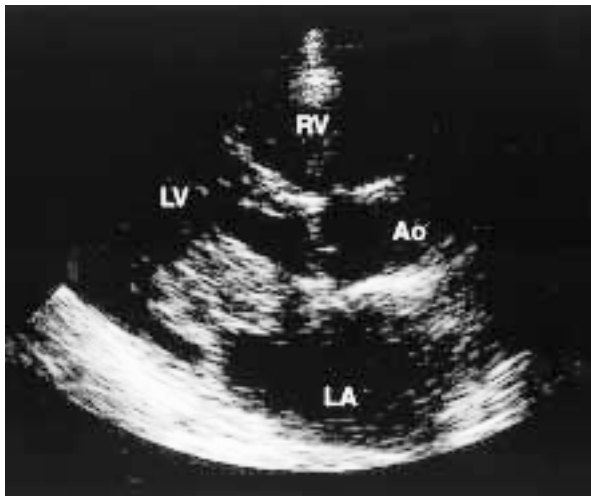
Transthoracic echocardiogram in the parasternal long-axis view
